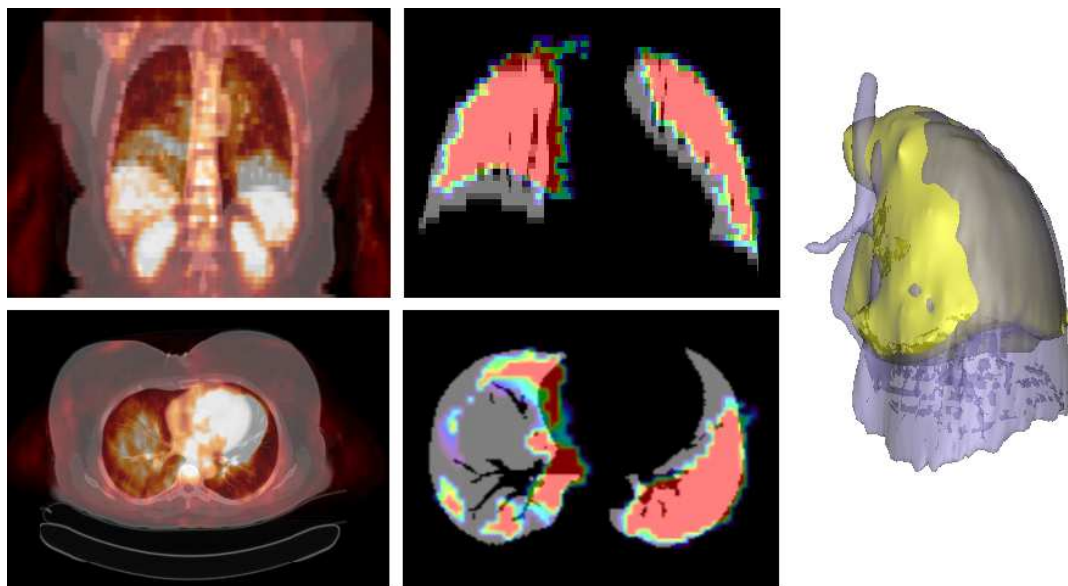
Linear registration results in a thoracic case. Left: coronal (top) and axial (bottom) slices of the superimposition of CT (grey) and registered PET (red temperature) images. Center: coronal (top) and axial (bottom) slices of the superimposition of CT (grey) and registered PET (red) segmented lungs. Right: 3D superimposition of CT (blue) and registered PET (yellow) rendered lungs. The three different displays prove that a linear transformation cannot cope with deformations suffered by some thoracic structures such as the lungs.
